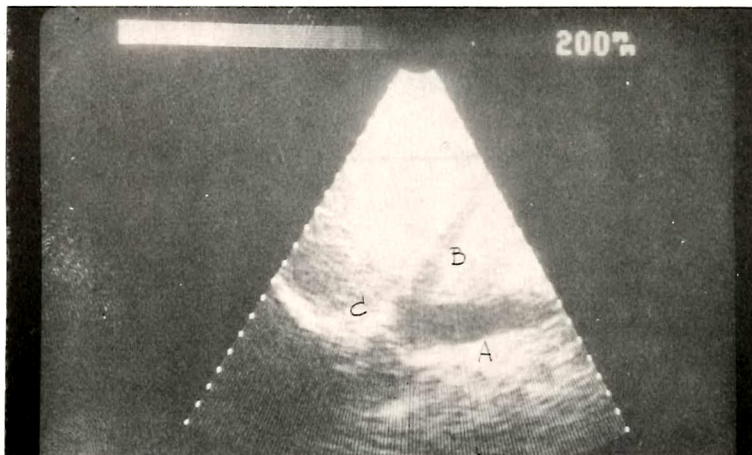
Ultrasonogram of I.V.C. show obstruction above hepatic vein. I.V.C. show by A, hepatic vein B, right atrium C.
